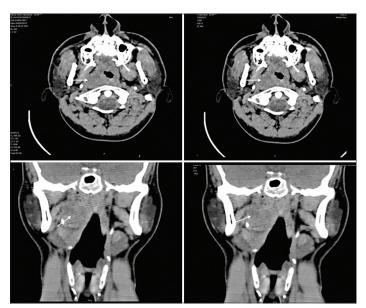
Correlative plain computed tomography scan of neck demonstrating a large retropharyngeal lymph node (3.5 cm  $\times$  3.0 cm  $\times$  2.8 cm) on the right side which in the setting of intense iodine uptake suggested a the diagnosis of metastatic retropharyngeal lymph node
